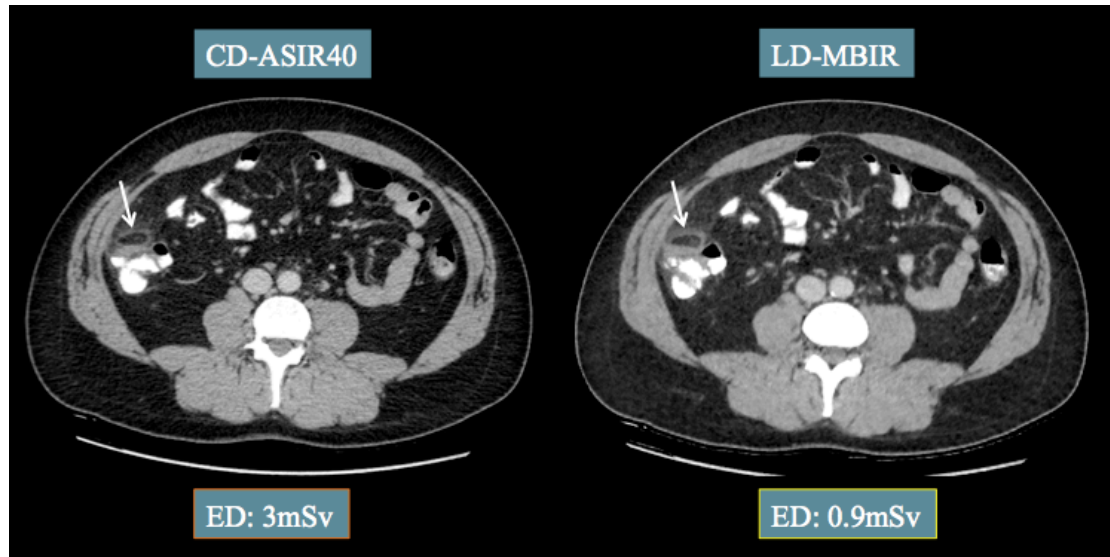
CD-ASIR and LD-MBIR coronal CT images in a 28 year-old male patient presenting with acute abdominal pain show a tortued epiploic appendage of the ascending colon. The LD-MBIR image was acquired at a significantly lower dose than the CD-ASIR image.
